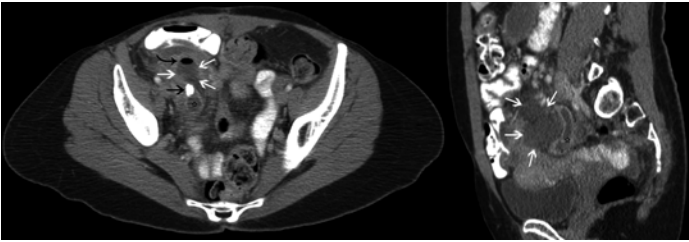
Axial and coronal CT images displaying a case of perforated appendicitis. The tubular shape of the appendix (*asterisks*) is clearly seen in the coronal view with a high-density fecalith (*black arrow*) best seen on the axial view. Gas (*curved black arrow*) within the surrounding fluid collection (*surrounded by white arrows*) is consistent with peri-appendiceal abscess formation.
